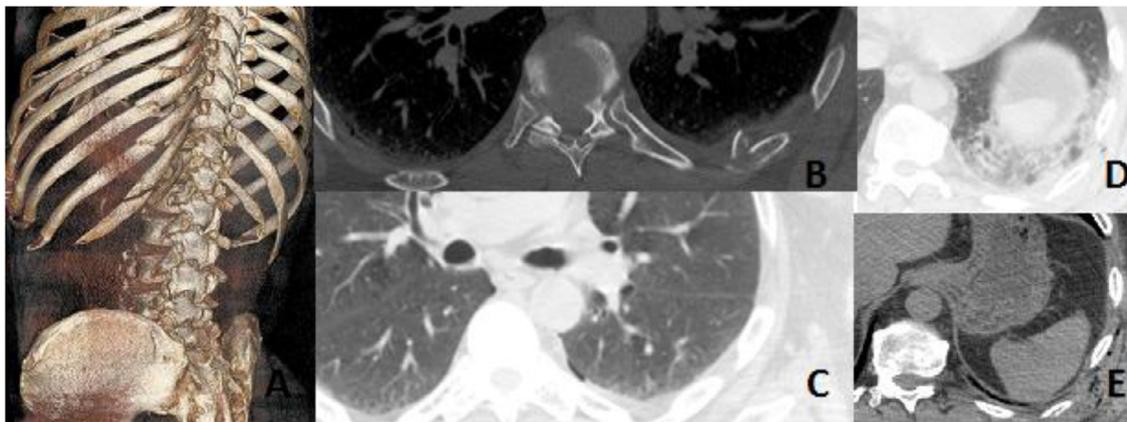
Computed tomography (CT) examination. A 71-year-old man hit by a bar with multiple rib fractures, minimal pneumothorax, soft tissue emphysema and left pulmonary contusion (A-E).
